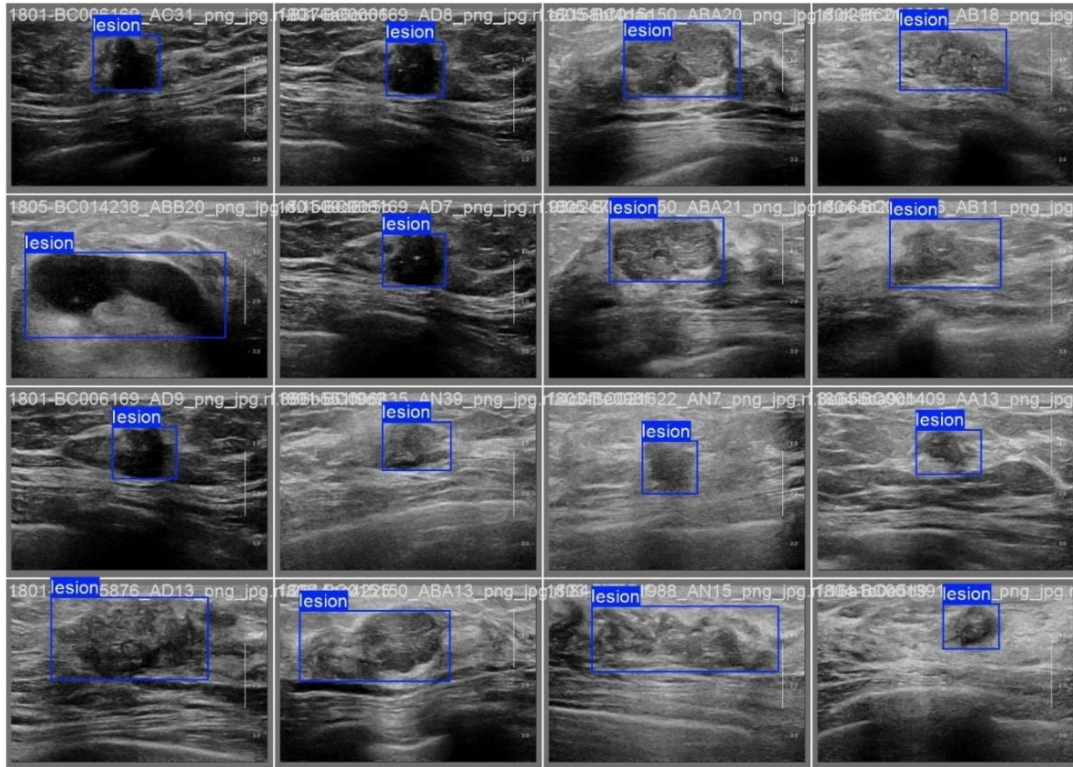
Qualitative Results of Lesion Detection and Localization on Breast Ultrasounds
